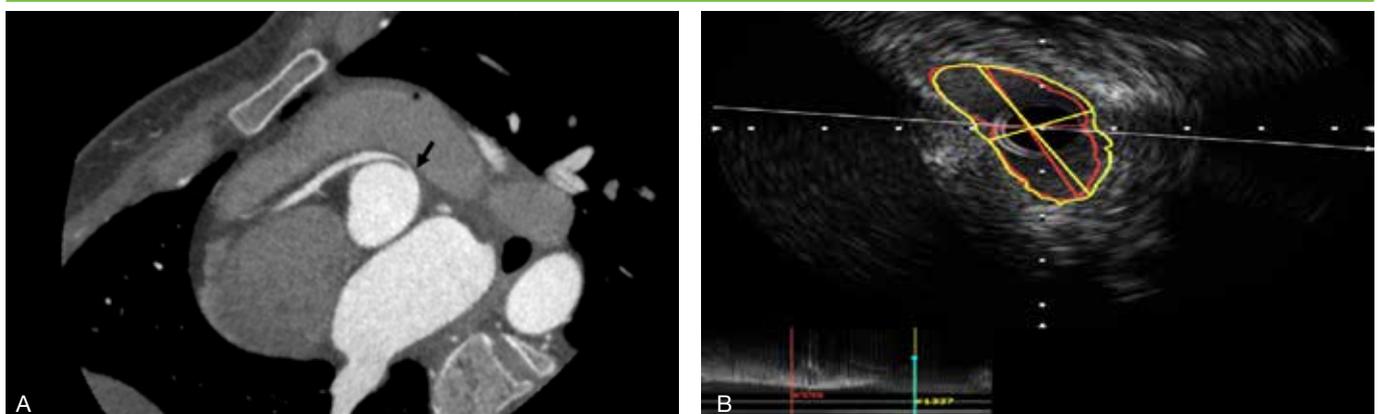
Coronary artery anomaly on contrast-enhanced MDCT with significant narrowing confirmed on intravascular ultrasound (IVUS) in a 40-year-old lady with exertional angina. (
